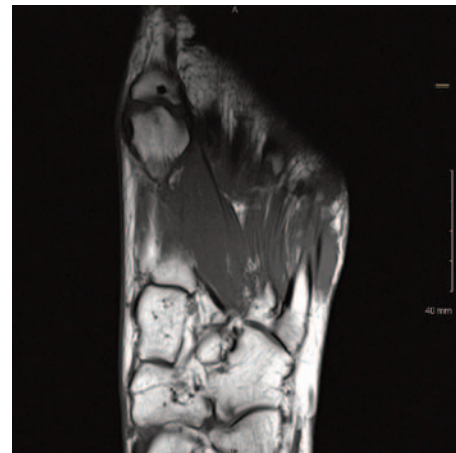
T2-weighted image at 1 year following treatment with complete resolution of symptoms
